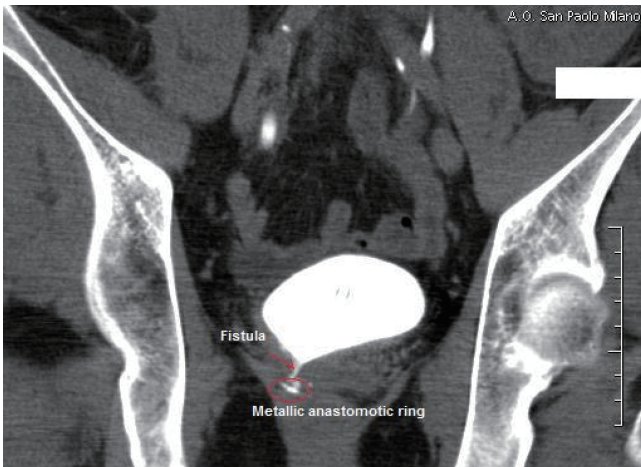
CT scan showing the residual rectovesical fistula
